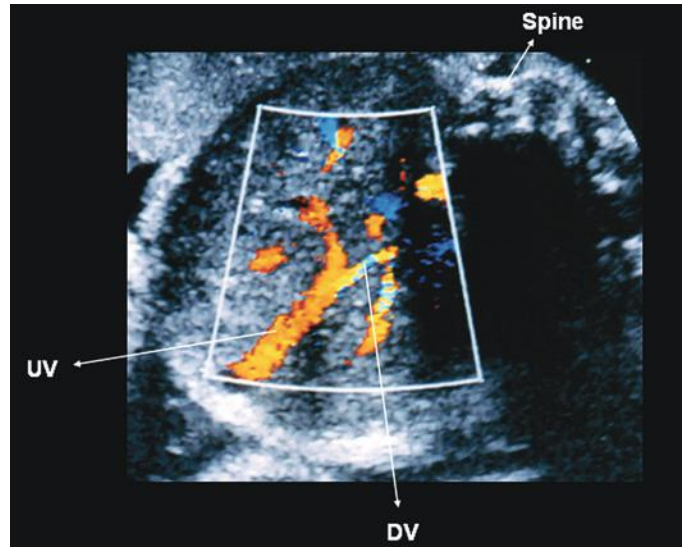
Color Doppler sonogram of a transverse plane of the fetal abdomen showing the umbilical vein (UV) and the ductus venosus (DV). Note the presence of turbulence (with aliasing) on color Doppler in the ductus venosus.
